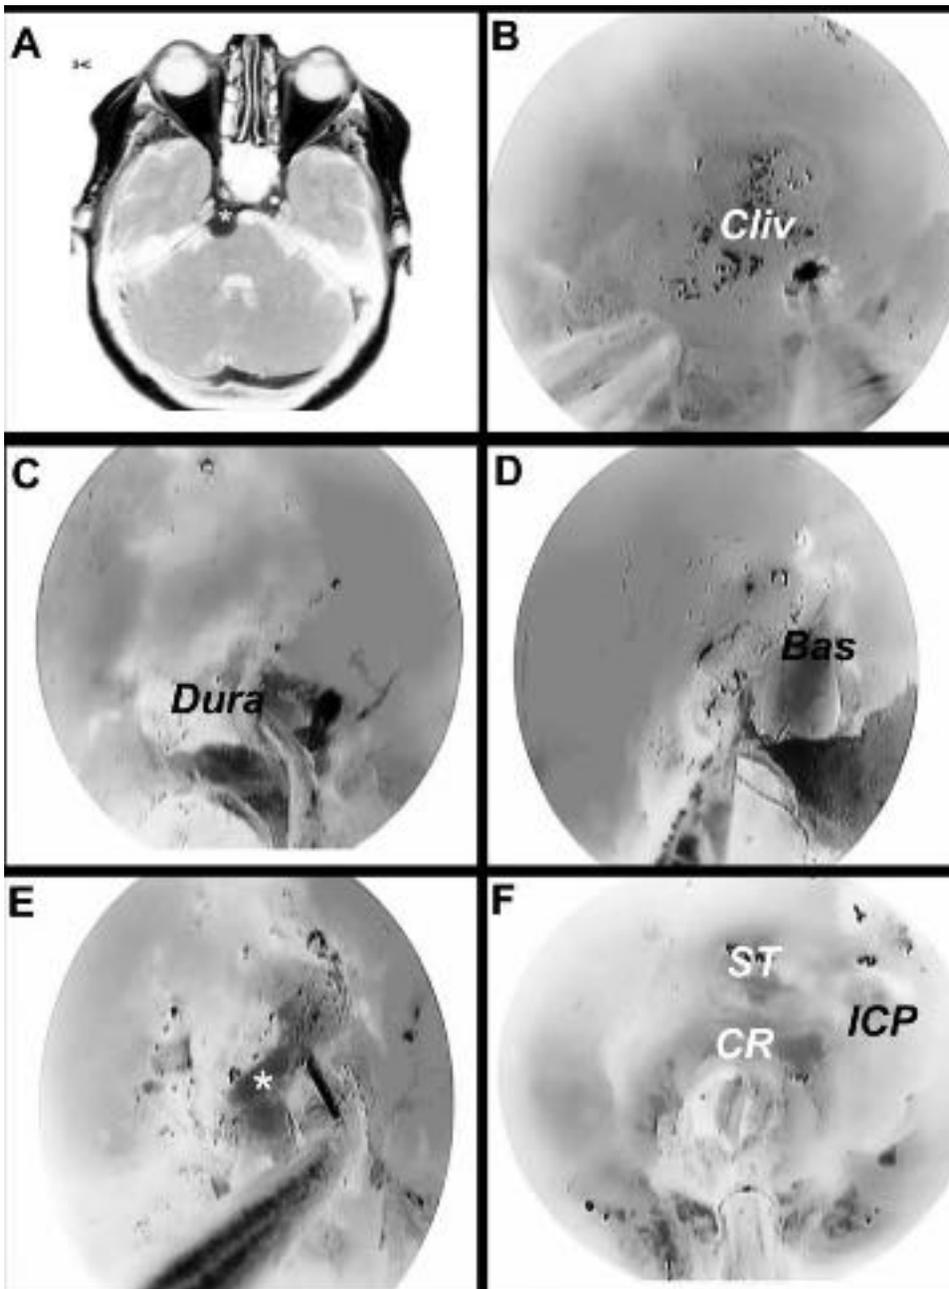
Endonasal approach to clival meningioma. (A) Magnetic resonance imaging T1 with gadolinium contrast revealing a small clival lesion just right of the midline. (B) Clivus approach via endoscopic endonasal approach. (C) After drilling the clivus and linear durotomy, the dura is reflected with a blunt dissecting hook. (D) Basilar artery revealed underneath dura, highlighting the danger of this approach. (E) Tumor bulk gently removed via suction. (F) Anatomy of the clivus, seen under the sella turcica, the carotid protuberance forming its superior-lateral boundary. *, tumor; Bas, basilar artery; CR, clival recess; ST, sella turcica; ICP, left carotid protuberance.
